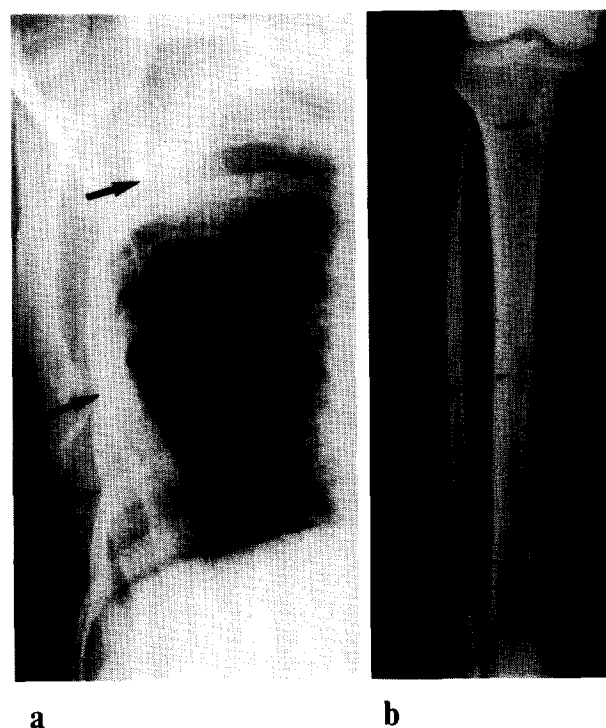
(a) Radiograph of the right rib showing multiple expansive ground glass lesions (black arrows) of the 2nd, 6th and 7th rib. (b) Radiograph of the right tibia showing a radiolucent lesion (black arrow) with marginal sclerosis in the proximal diaphysis and a radiolucency without marginal sclerosis (black arrowhead) in the metaphysis.
